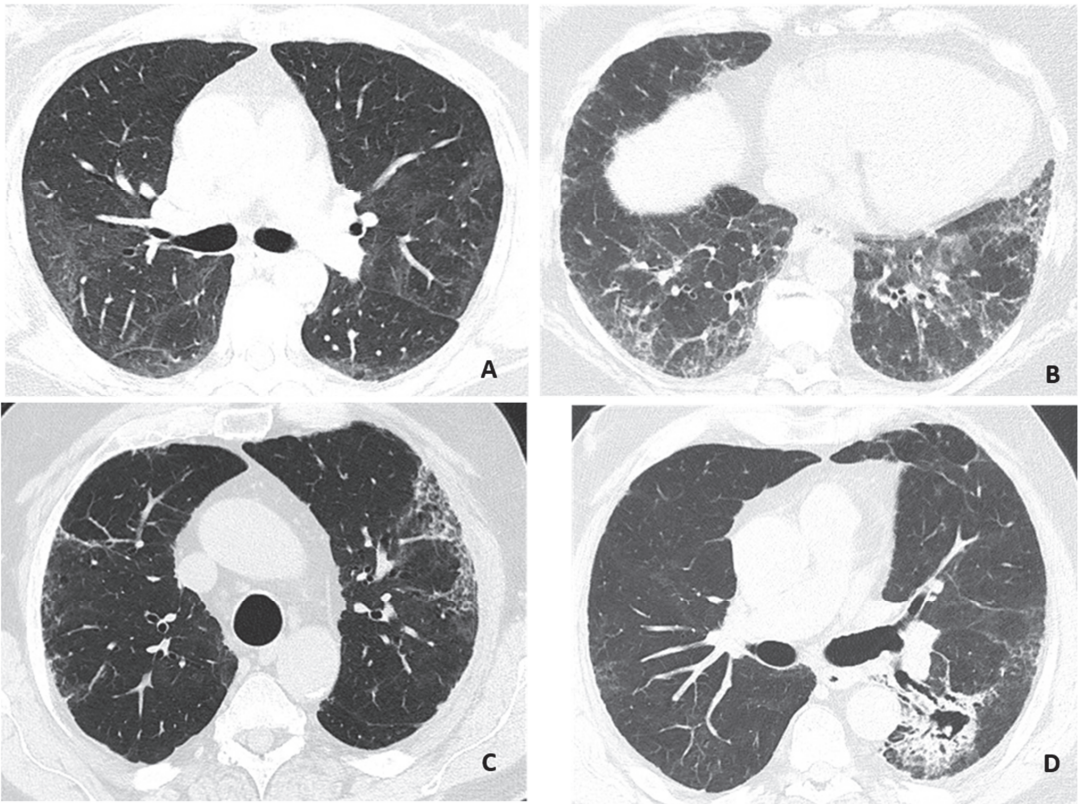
Representative findings on HRCT-scans. (A) Ground-glass opacity with discrete interlobular lines. (B) Ground-glass opacity with a reticular pattern. (C) Discrete ground-glass opacity with reticular pattern and honeycombing. (D) Fibrosis with traction bronchiectasis and infarct sequelae with possible fungus ball in the cavity. Images from three patients, (C,D) is from the same patient.
